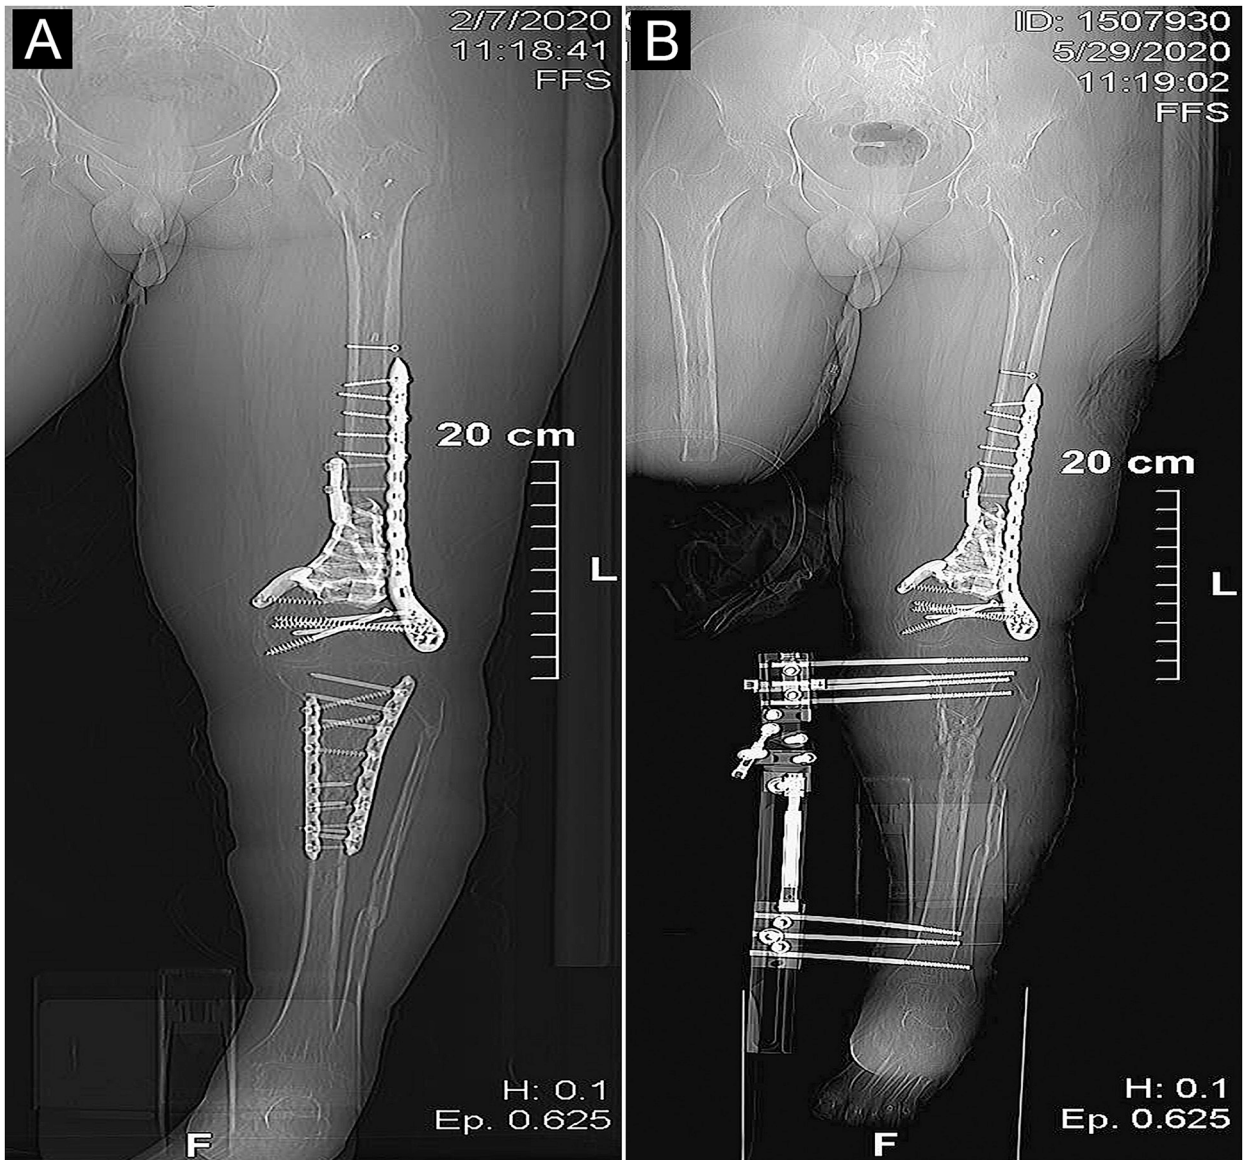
A. Axonometric view of the left lower limb 3-months after implantation of the femur and double ORIF of left tibia. The x-ray shows appropriate alignment and bone healing of the femur using the personalized 3D-printed implants well as the placement of one anterior lateral and one medial locking plates at 90° to each other on the left tibial fracture. Date of examination: 7, February 2020 as shown in the fig.
